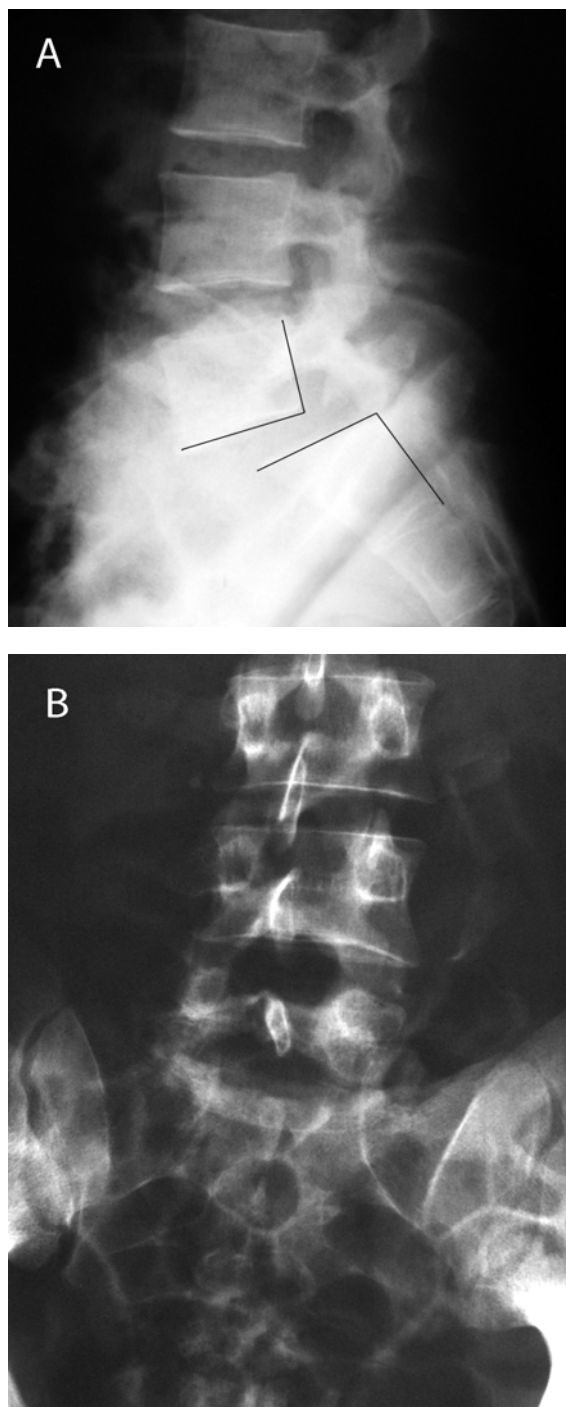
Preoperative X-ray showing 60% anterior dislocation L5-S1; A, lateral. B, anteroposterior
